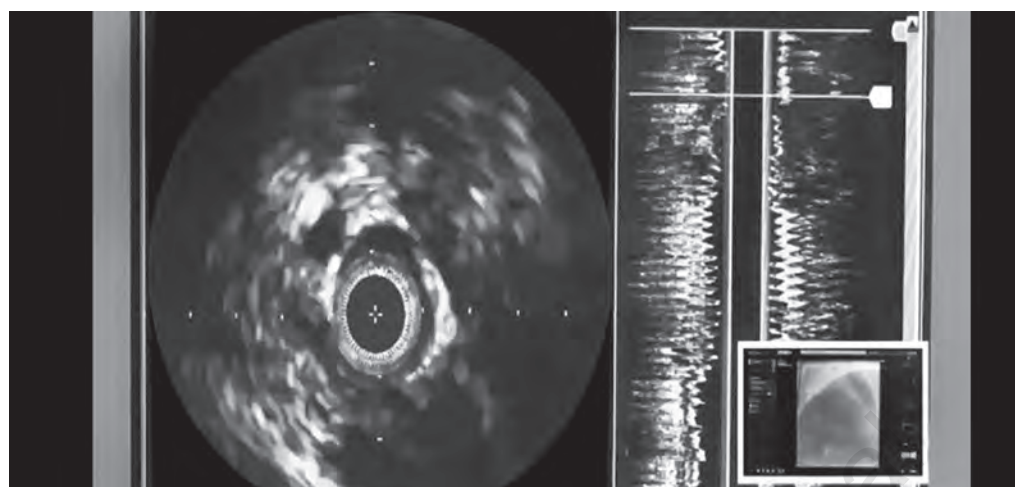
Intravascular ultrasound (IVUS) picture showing echolucent area between myocardial bridge segment and epicardium.
